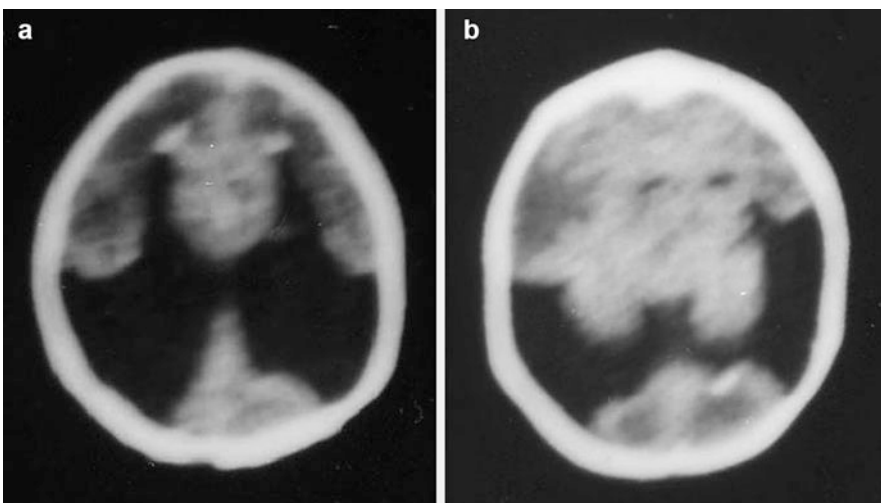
(a, b) MRI of the brain of another patient showing bilateral open-lip schizencephaly in the parietal regions in communication with a large cavity filled by cerebrospinal fluid
